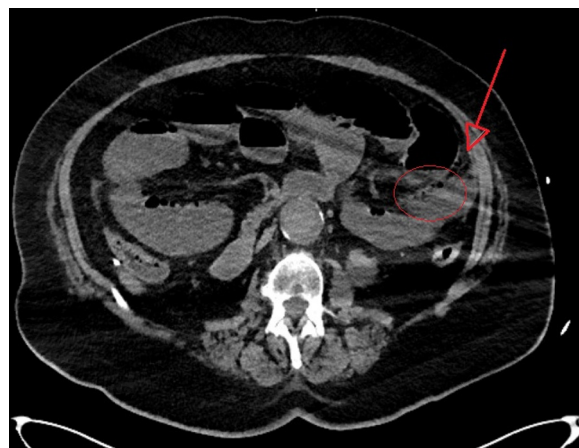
Selected axial CT image demonstrating mesenteric oedema (arrow) and pneumatosis intestinalis in thickened bowel wall (circle) consistent with ischaemic bowel in the left upper abdomen.
